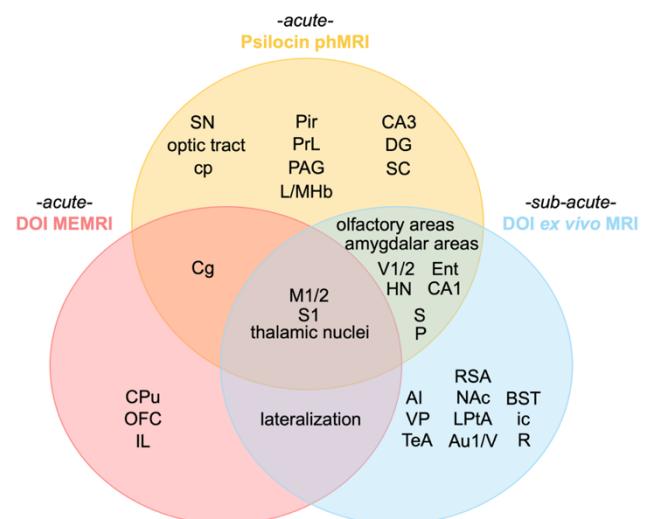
The overlap between brain areas that have shown psychedelic-dependent changes across two previous acute imaging studies and our results in the sub-acute phase. The overlapping results across all three studies are in primary and secondary motor cortices (M1/2), somatosensory cortex (S1), and various thalamic nuclei. There are overlaps with the acute psilocybin study (Spain et al., 2015) in olfactory and amygdalar areas, visual cortex (V1/2), hypothalamic nuclei (HN), subiculum (S), pontine nuclei (P), entorhinal cortex (Ent), and CA1 of hippocampus. The areas specific to the pharmacological MRI (phMRI) following psilocybin are substantia nigra (SN), optic tract, cerebral peduncle (cp), piriform cortex (Pir), prelimbic cortex (PrL), periaqueductal grey (PAG), lateral and medial habenula (L/MHb), dentate gyrus (DG), CA3 of the hippocampus, and superior colliculus (SC). The overlap between only the two acute studies is in cingulate cortex (Cg). The signal changes distinct to only the acute manganese-enhanced MRI (MEMRI) with DOI (Malkova et al., 2014) are in caudate putamen (CPu), orbital areas (OFC), and infralimbic area (IL). Lateralized effects are reported in both studies with DOI. Changes that are specific to our sub-acute study are in agranular insular cortex (AI), ventral pallidum (VP), temporal association area (TeA), the nucleus accumbens (NAc), lateral parietal association cortex (LPtA), primary and secondary ventral auditory cortex (Au1/V), bed nucleus of stria terminalis (BST), internal capsule (ic), red nucleus (R), and retrosplenial area (RSA).
